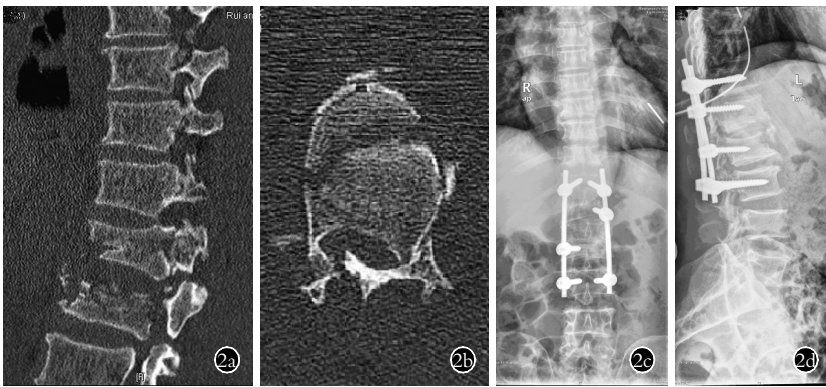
患者,男,62 岁, L₁、L₂ 爆裂性骨折 2a, 2b. 术前腰椎 CT 示 L₁、L₂ 爆裂性骨折,后凸畸形 2c, 2d. 术后 3 d 腰椎正侧位 X 线片示椎体高度恢复
